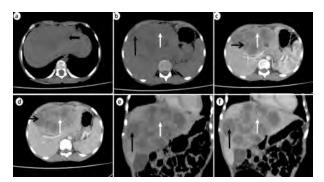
(a) Axial plain CT images reveal a large ill-defined heterogeneously hypodense mass lesion involving left and right lobes (segment VIII and IV) of liver; (b) Cystic appearing areas (black arrow) as well as solid slightly hyperdense areas (white arrow) seen within the lesion. Contrast enhanced CT scan shows axial images: late arterial phase (c) and porto venous phase (d), composed of solid and cystic areas. Cystic areas (black arrow) show no significant enhancement whereas solid areas show mild progressive enhancement (white arrow); Contrast enhanced CT scan shows coronal images of the lesion. (e) late arterial phase, (f) porto venous phase. Lesion is composed of solid and cystic areas. The cystic areas (black arrow) show no significant enhancement (white arrow).
